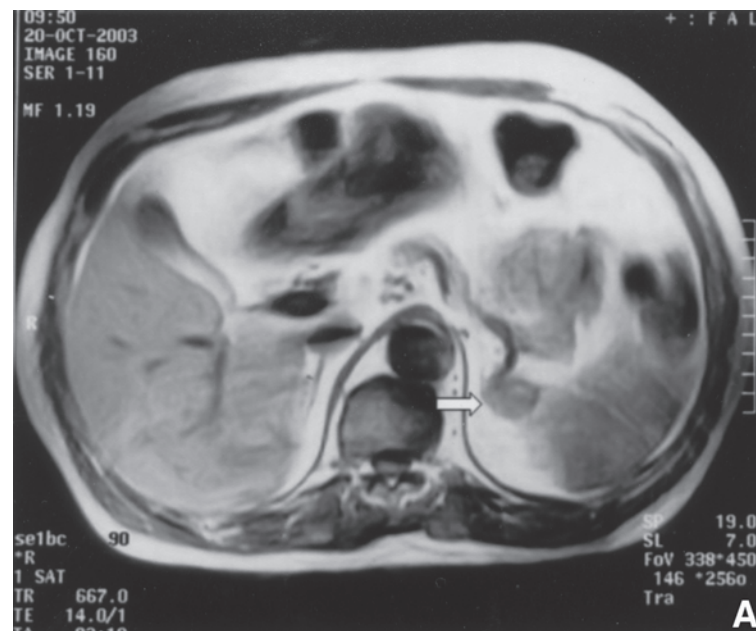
T₁-weighted magnetic resonance image demonstrating round homogeneous tumor with isointensity signal at the left adrenal gland (A) (arrow).
